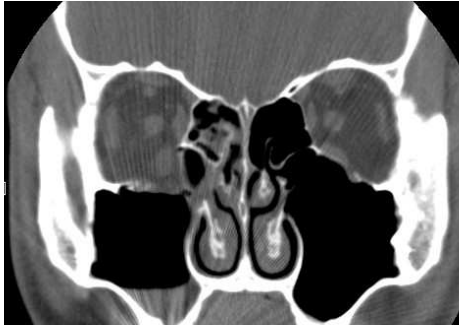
Grade I blowout fractures. (a) Minimal inferior wall fracture with soft tissue entrapment in the coronal CT image. (b) Minimal medial wall fracture in the axial CT image.
